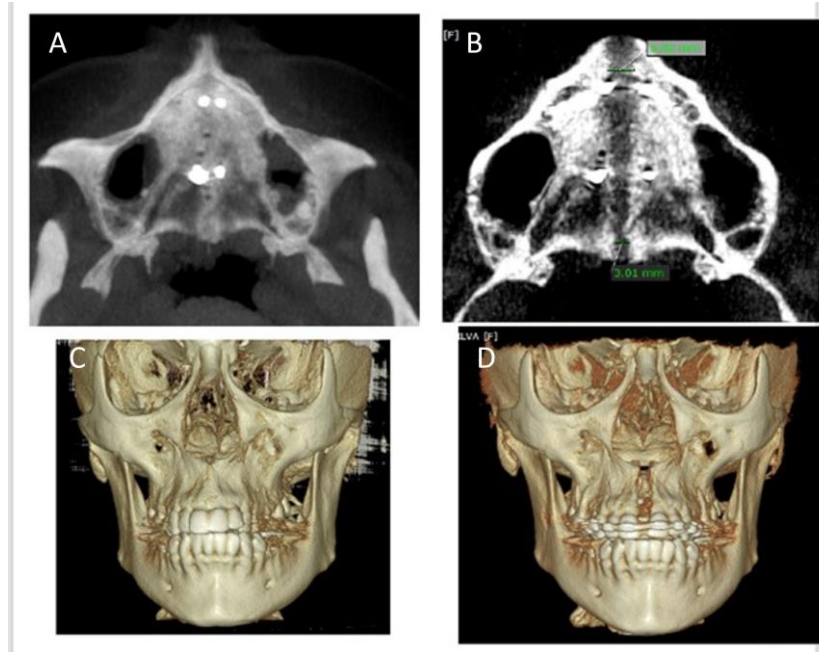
CBCT images: A, axial tomographic section pre-expansion. B, axial tomographic section post expansion. C, 3D reconstruction pre-expansion. D, 3D reconstruction post expansion.
